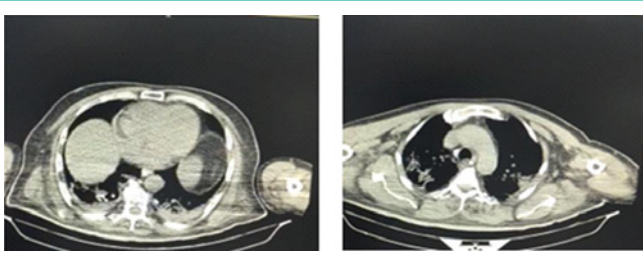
Computed tomography 48 hours after intralipid infusion.
